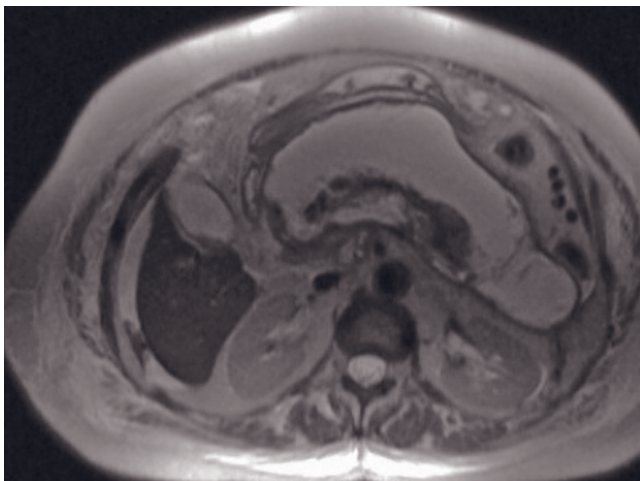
Intraductal papillary mucin secreting neoplasm—main duct type. T2-weighted echo-train spin-echo (a), thick-slab MRCP (b), immediate postgadolinium fat-suppressed SGE (c), and interstitial-phase gadolinium-enhanced fat-suppressed
